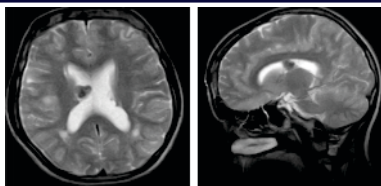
MRI, T2W axial(A) and Sagittal (B) images showing Calcified subependymal nodules
